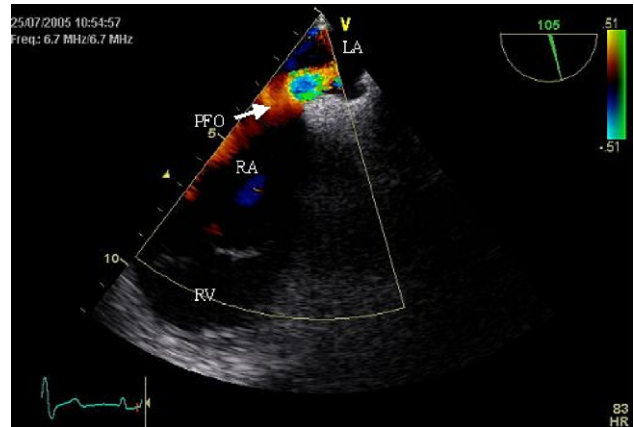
Transesophageal echocardiography demonstrating a right to left shunt through a patent foramen ovale (PFO). LA: left atrium, RA: right atrium, RV: right ventricle.
